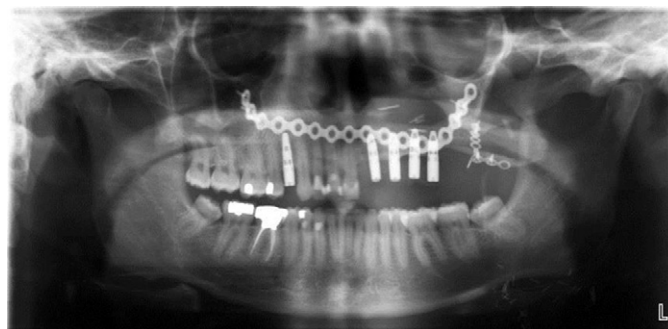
Panoramic radiograph of implants placed into fibula. Same patient as in Figs. 15 and 16.
